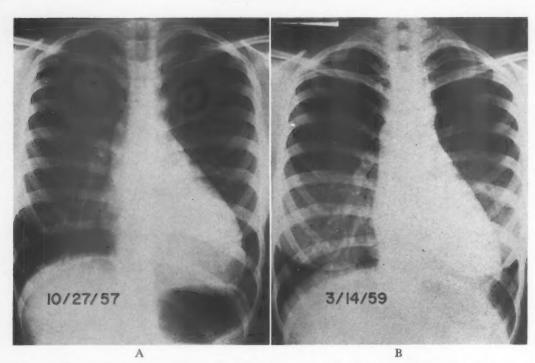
Posteroanterior roentgenograms of the chest. A, first admission, showing enlargement of the heart, straightening of the left border and normal lung fields. B, second admission, two weeks postoperative, showing considerable reduction in heart size.
